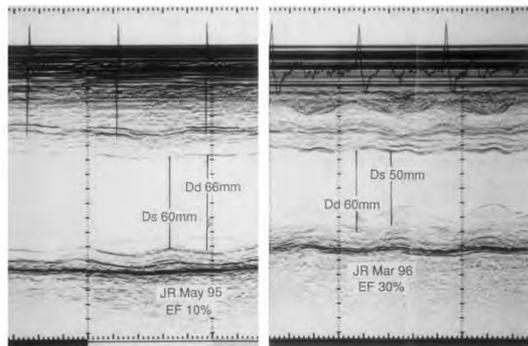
M-mode echocardiographic image showing reduction in LVESD and LVEDD before (left) and after (right) sustained DHBP. Ds indicates systolic dimension; Dd, diastolic dimension; EF, ejection fraction; JR, patient identifier.
